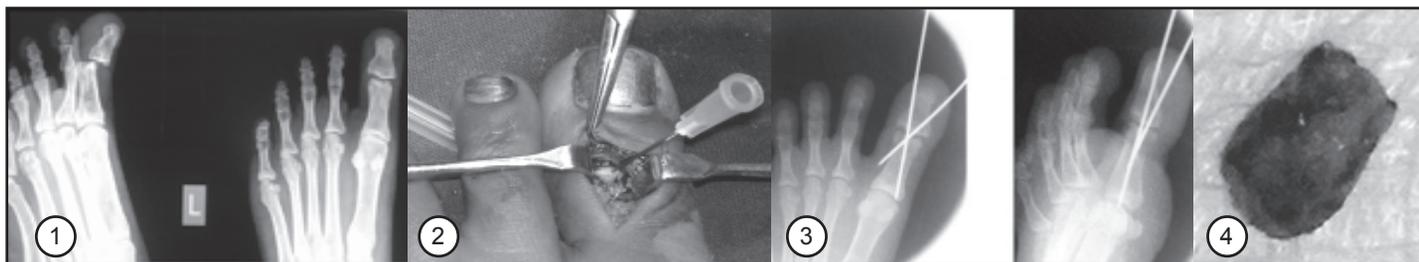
Pre-operative lateral and antero-posterior radiograph showing the interposed sesamoid bone in the proximal hallux interphalangeal joint of the left foot; Figure 2: Intraoperative view of the interposed sesamoid bone marked with the needle; Figure 3: a) Antero posterior and, b) Oblique intra-operative photographs showing good reduction after ORIF; Figure 4: Excised sesamoid bone.
